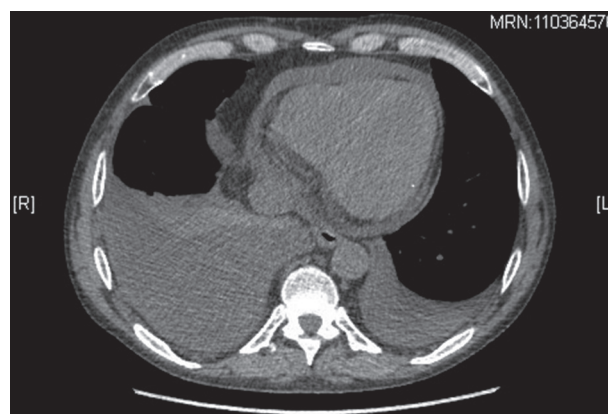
CT scan of pleuropericarditis at diagnosis.
